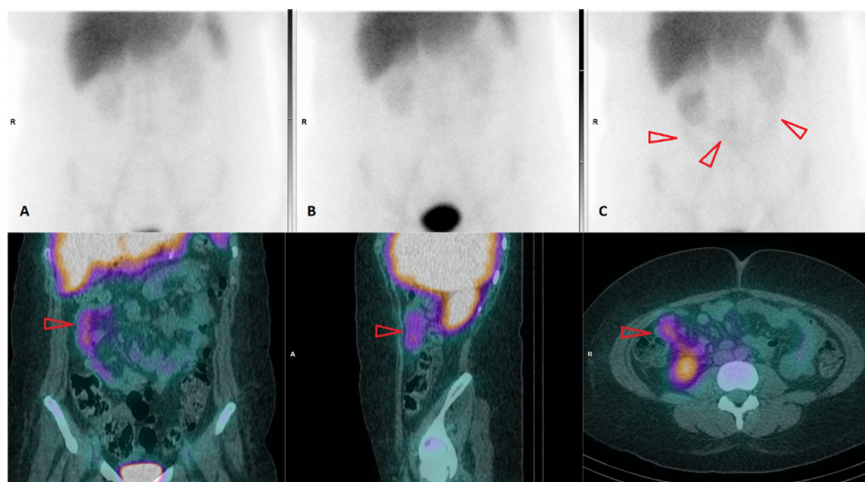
Representative anterior projection planar images of the abdomen at (A) 1 hour, (B) 2 hours and (C) 4 hours, with the 4-hour images showing several regions of faint bowel activity (arrowheads). Fused single-photon emission computed tomography (SPECT)/CT images localises the activity to the small bowel (arrowheads).
